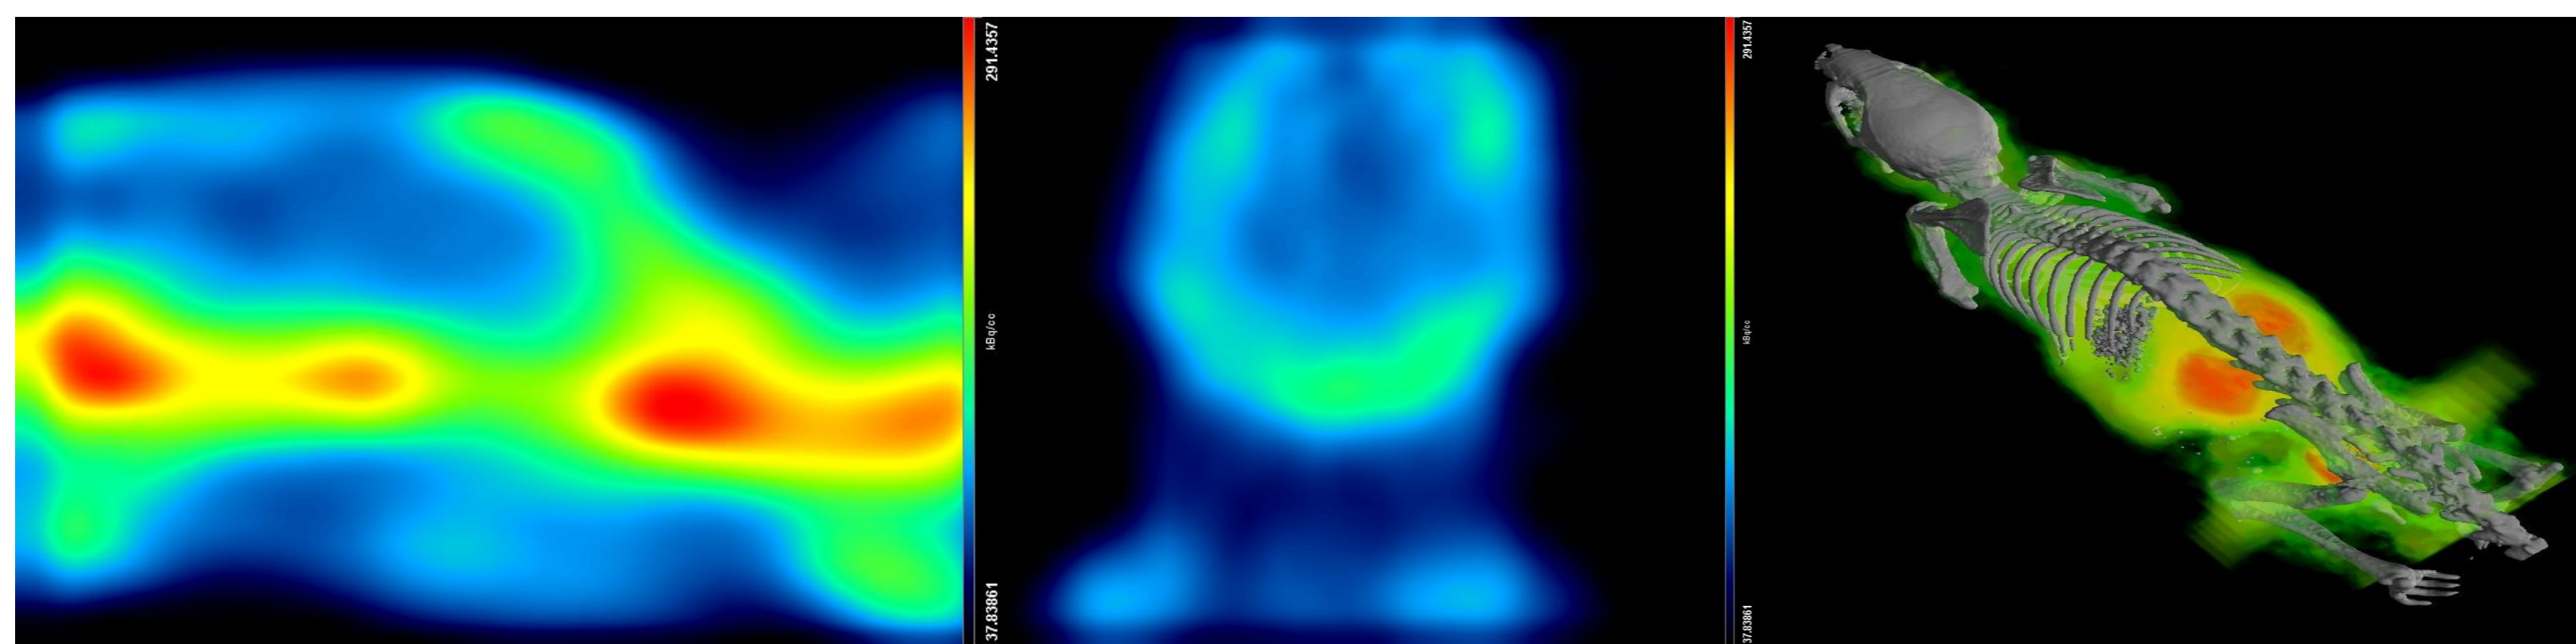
Brain uptake and 3D representation of co-registered micro PET/CT image (left: sagittal plane through brain and skull, middle: coronal plane through brain and skull, right: 3D segmentation)
